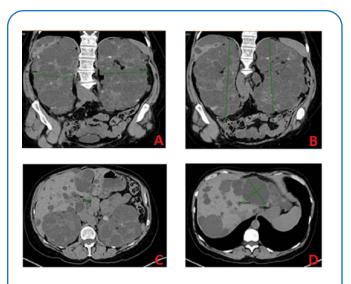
A: Abdominal CT scan with transverse measurement of polycystic kidneys 9 cm right and 10 cm left; B: CT of the abdomen with longitudinal measurement of polycystic kidneys 22.9 cm right and 21.6 cm left; C: CT scan with cystic images in the liver; D: CT scan with cystic images in the liver.
